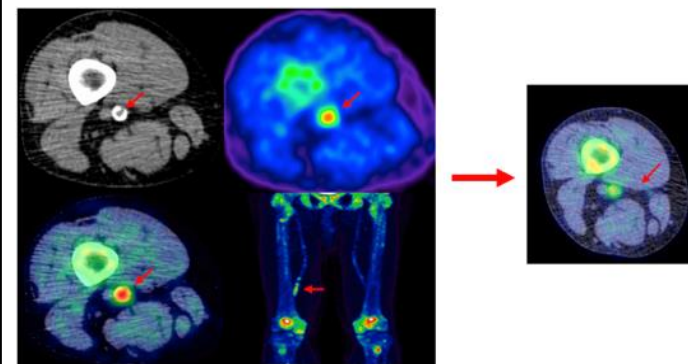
Figuerola AL, Abdelbaky A, Truong QA, et al. Measurement of arterial activity on routine FDG PET/CT images improves prediction of risk of future events. *JACC Cardiovasc Imag.* 2013; 6(12):1250-1259.
